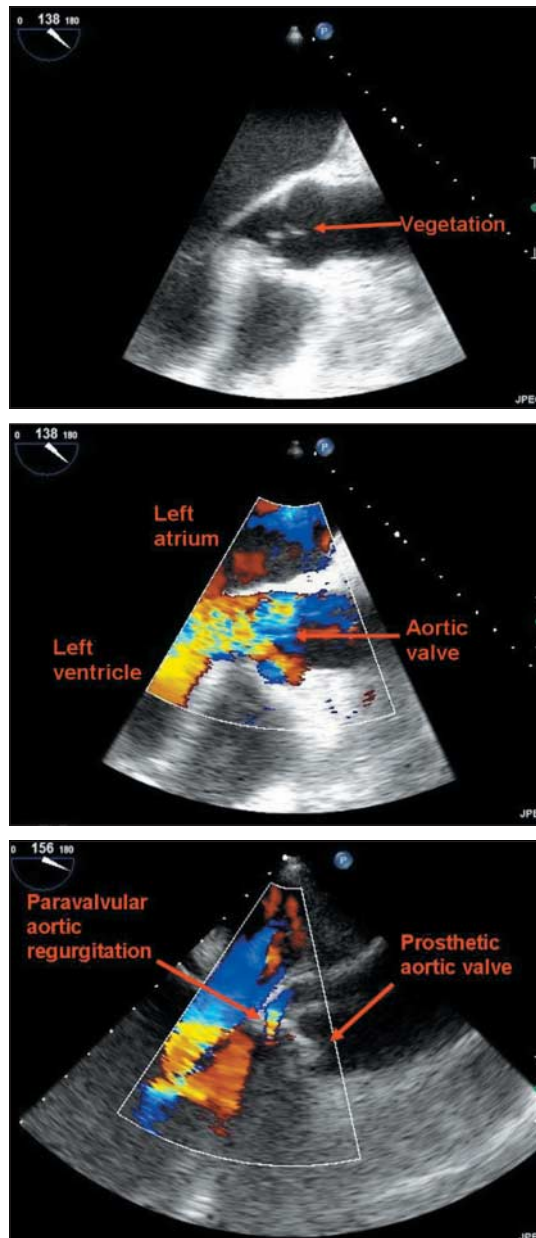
Role of transoesophageal echocardiography in investigation and management of endocarditis. Top: small vegetation on tip of a coronary cusp undetected by transthoracic echocardiography. Middle: same patient as above, showing resultant severe aortic regurgitation. Bottom: paravalvular aortic regurgitation in patient with endocarditis affecting a prosthetic aortic valve
